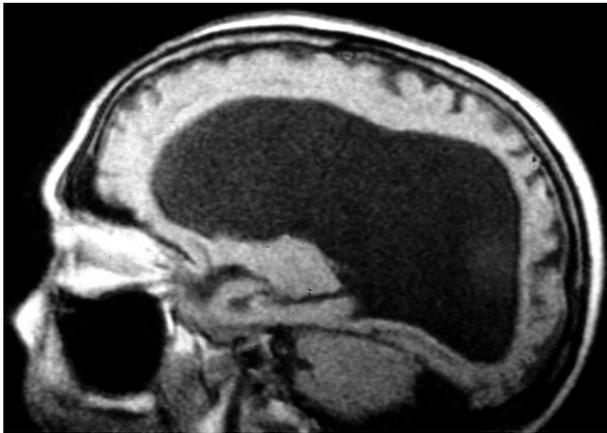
This MR image shows the massive dilatation of the lateral ventricle in an individual with obstructive hydrocephalus. Note the remarkable thinning of the cerebral cortex
